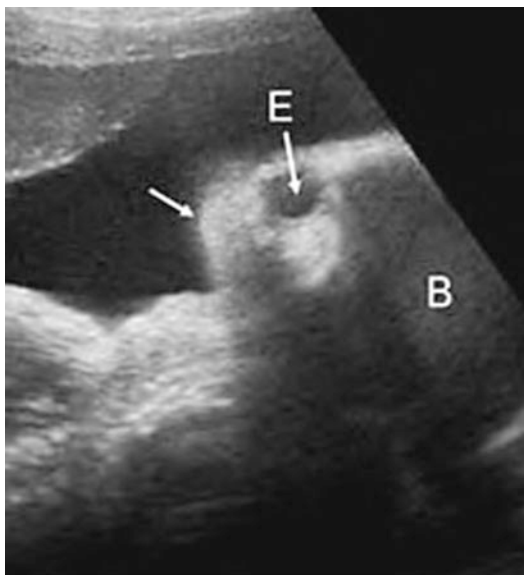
Prenatal ultrasound showed absence of fetal jaw (*arrow*) (*E* fetal eye, *B* fetal brain)
